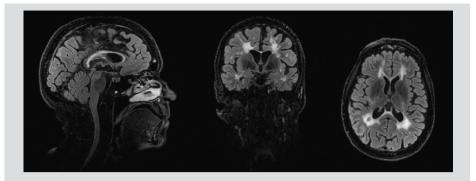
Example of a FLAIR sequence of an individual with MS. Hyperintensities are visible around the ventricles.
